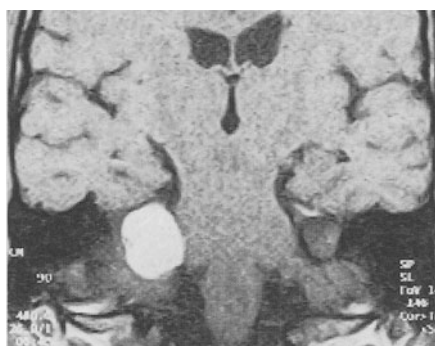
Postcontrast MR (TR 480, TE 26) demonstrating enhancing right-sided acoustic neuroma from a Siemens 0.2-T open MR system. (Mark Leszczynski, RT, Memorial Open MRI, Houston, Texas, used with permission)
